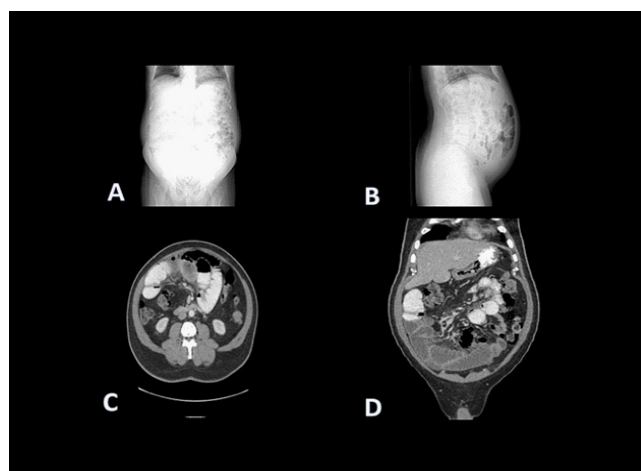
Computed Tomography (CT) Abdomen and pelvis (A) Scout Image showing distended abdomen. (B) Scout image showing dilated loops of bowel in sagittal view. (C) Evidence of dilated loops of bowel with contrast transition in mid-abdomen in axial view. (D) Coronal view of dilated loops of bowel and contrast reaching likely transition point in the mid-abdomen.
